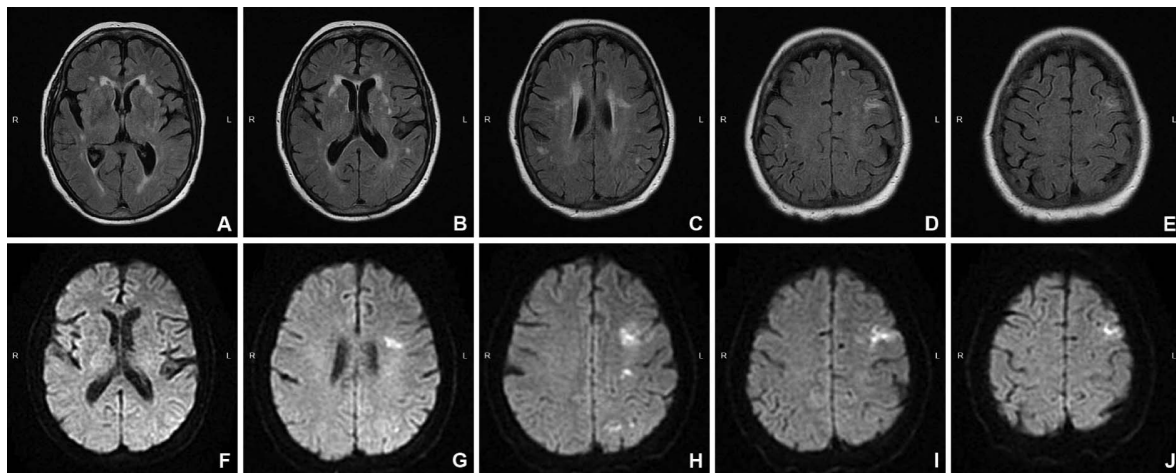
Brain MRI axial FLAIR slices (A–E) 10 days post-stroke disclose widespread small subcortical white matter and basal ganglia lesions and a larger infarction in BA6 (at a depth of 1.5 cm) of the left hemisphere. DWI of the brain (F–J) shows in addition to the acute prefrontal infarction, two additional small acute ischemic lesions in the white matter of the left parietal lobe.
